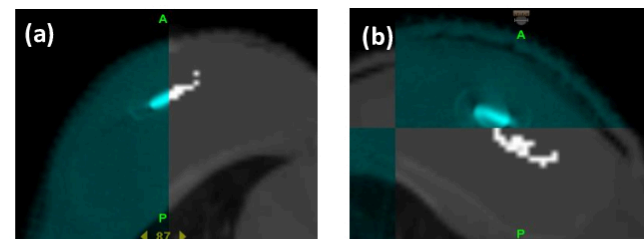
Checkered view of an MVCT image in the treatment position (turquoise) superimposed on the reference CT (gray) for two fractions. In (a) the metal port matches its original position and in (b) the metal port is displaced from its original position.
